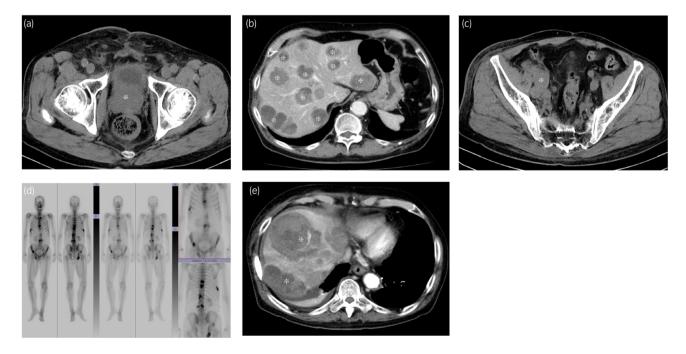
(a–c,e) CT of the abdomen. (a) Low-defined prostate tumor (*). (b) Multiple tumor burden in the liver (*). (c) Pelvic lymphadenopathy (*). (d) Bone scan. Multiple bone metastases. (e) Hemorrhage from liver metastases (*).
